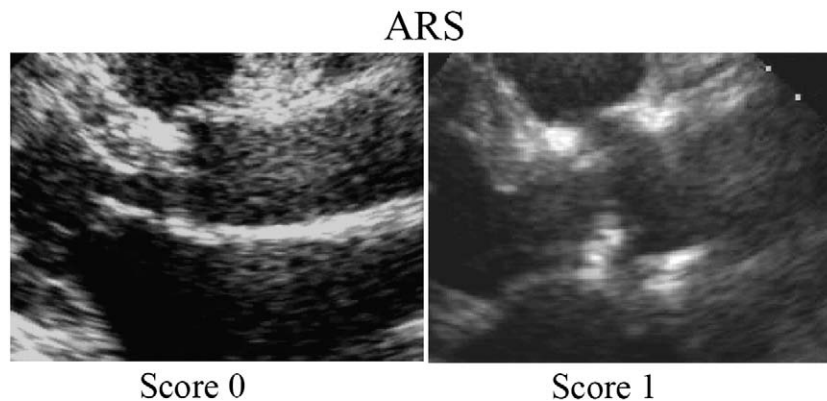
Quantification of ARS — transthoracic parasternal long axis view; score 0 — normal aortic root, score 1 — enhanced echogenicity of the aortic root.
